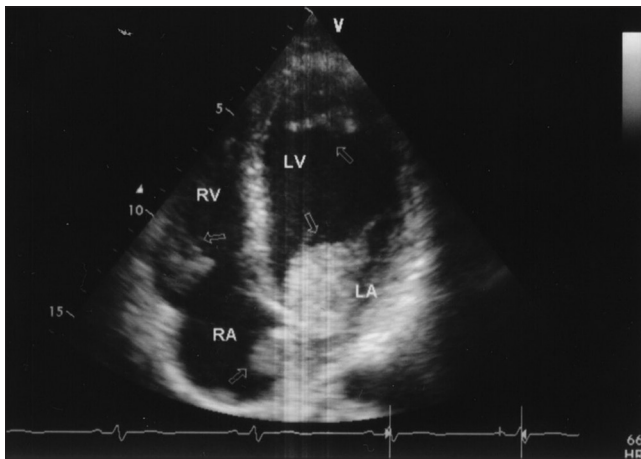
Patient's echocardiography in admission
